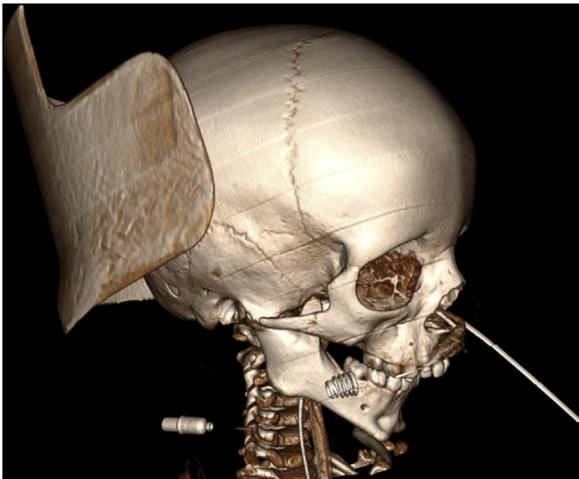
Three-dimensional reconstruction of the computed tomogram of the head showing the prominent coronoid process that contributed to the limited opening.
